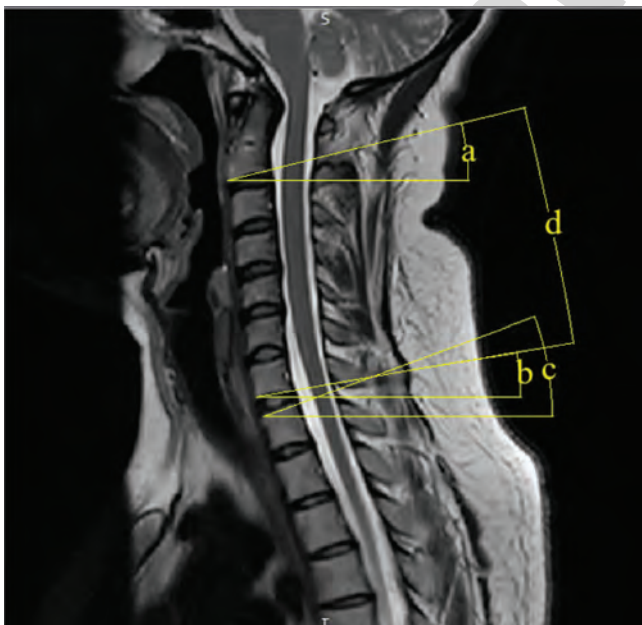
Radiograph showing several sagittal parameters measured in this study: a: C2 slope angle; b: C7 slope angle; c: T1 slope angle; d: cervical lordosis (C2–C7) angle
